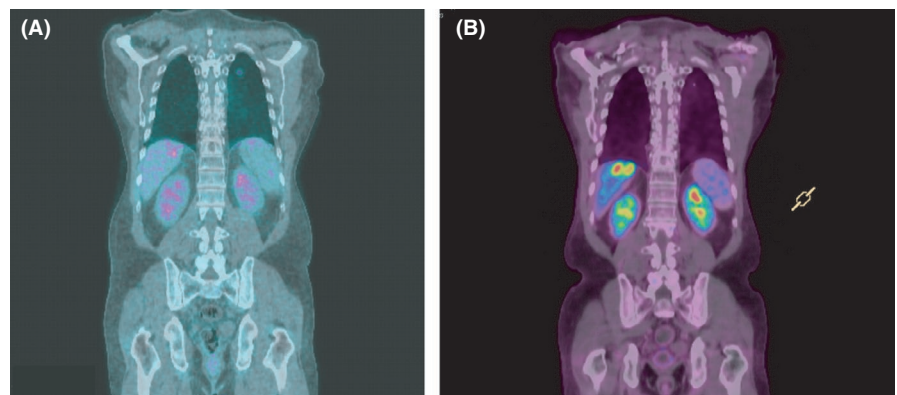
(A) PET-CT in July 2019; (B) PET-CT in March 2020. PET-CT, positron emission tomography-computed tomography
